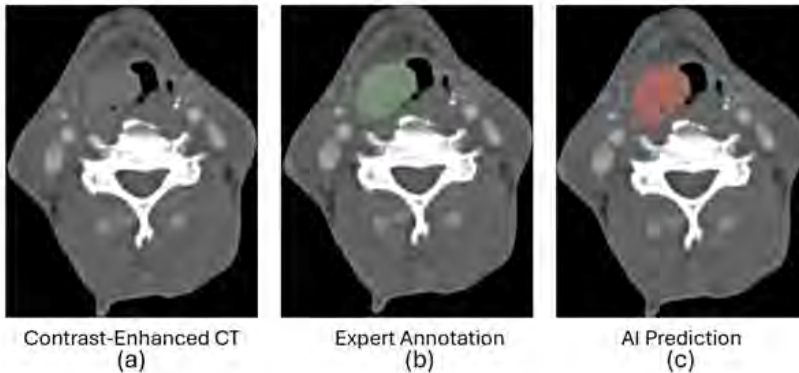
Internal Test Set Model Performance. (a) Shows the original contrast enhanced CT scan of the patient. (b) Shows the Expert's annotation of a lesion in green. (c) Shows the predicted location of the lesion identified by the model in red. Lesion DICE was 0.92.
